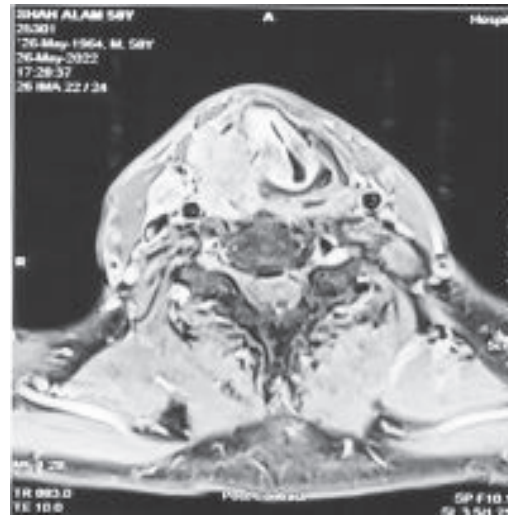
Post contrast T1WI MRI shows right sided thyroid mass extending into larynx.
